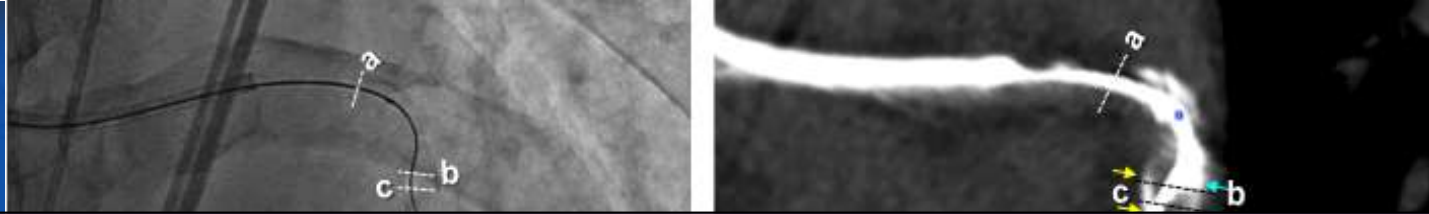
Coronary angiogram with bilateral injection (A & B) and pre-procedural curved multiplanar reformatted image (C). White arrows demonstrate CTO of the LAD with severe calcification. When the guidewire reached the distal lesion of the CTO, just before the distal true lumen (D), an intraprocedural CCTA was performed on site without contrast injection (E). Matching cross-sectional CCTA images showed the location of the guidewire in the coronary artery including CTO segments (F-J). Cross-sectional CCTA images at the wire tip level clearly showed the guidewire inside the intimal plaque of the CTO (H & I). The asterisks and blue and yellow arrows indicate the guidewire and calcified plaques, respectively. The CCTA system in the catheterisation room (K) comprised a CT scanner (a) and a coronary angiography system (b). Final post-procedural angiogram after successful stent implantation (L).
